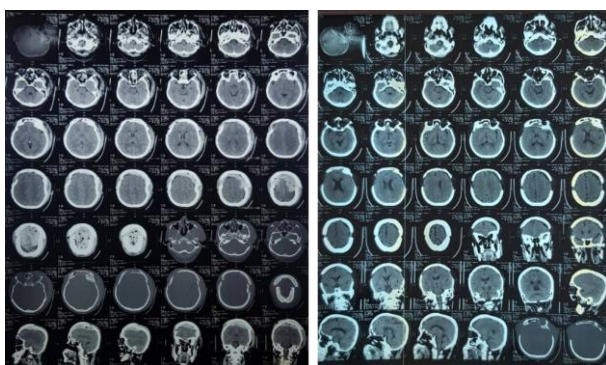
Pre (left) and postoperative (right) CT scans; note the hyperdense biconvex lesion on the vertex seen on preoperative CT.
